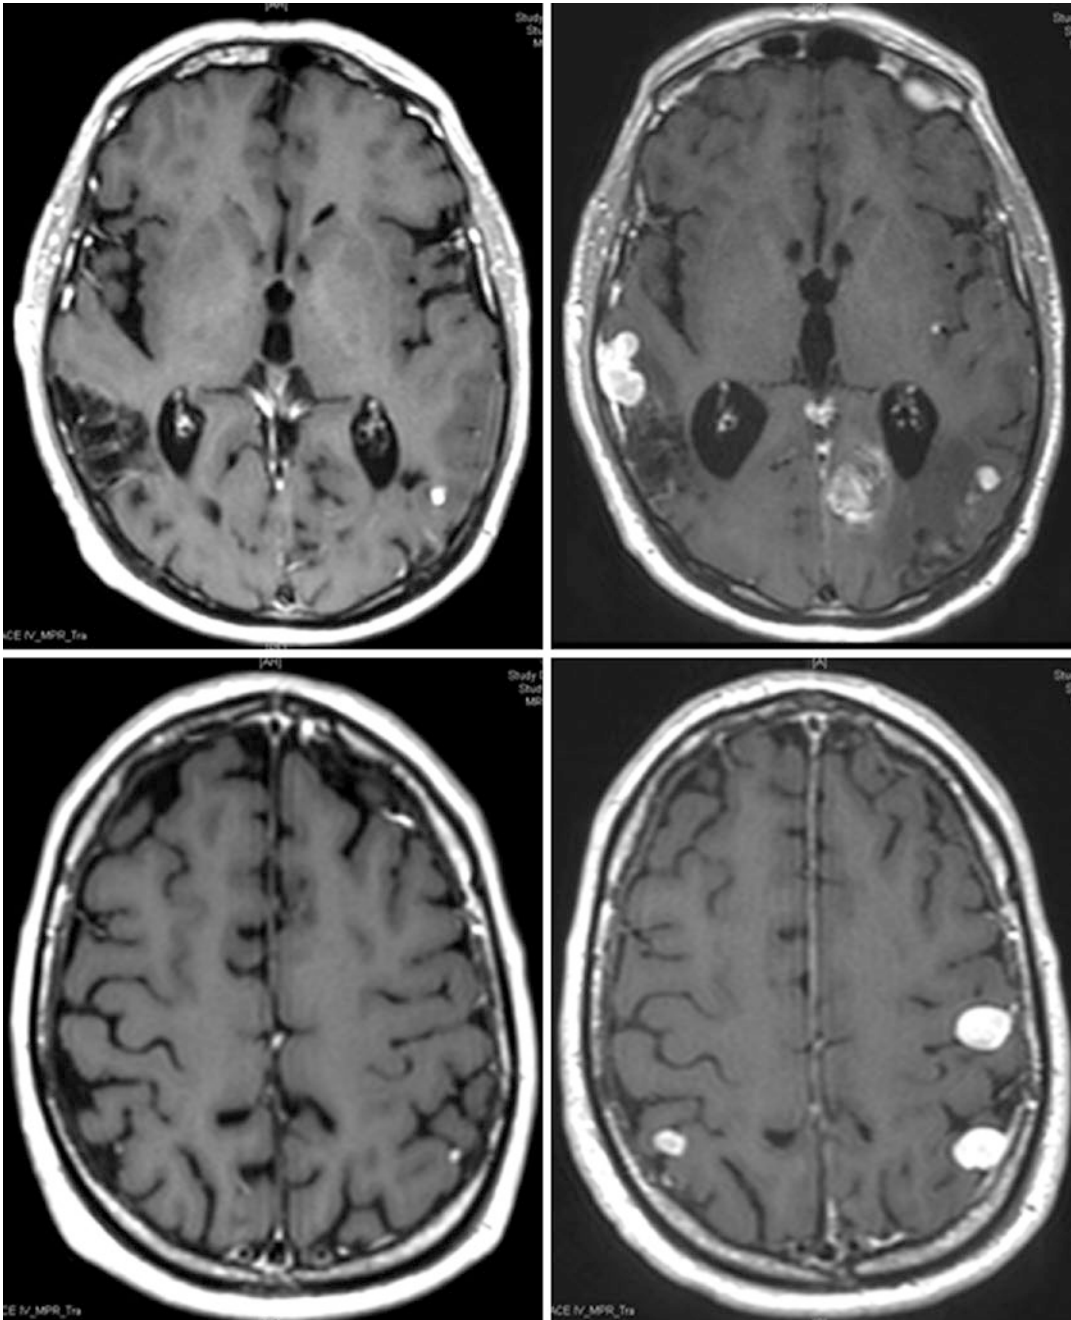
A healthy 55-year-old patient, recently metastatic from a melanoma, progressing extracranially with an anti-BRAF anti-MEK treatment who switched to a checkpoint inhibitor (pembrolizumab). Contrary to a previously normal investigation obtained 3 months ago, the MRI showed rapid emergence of nine new lesions, some of which are not well defined. The cumulative volume was
